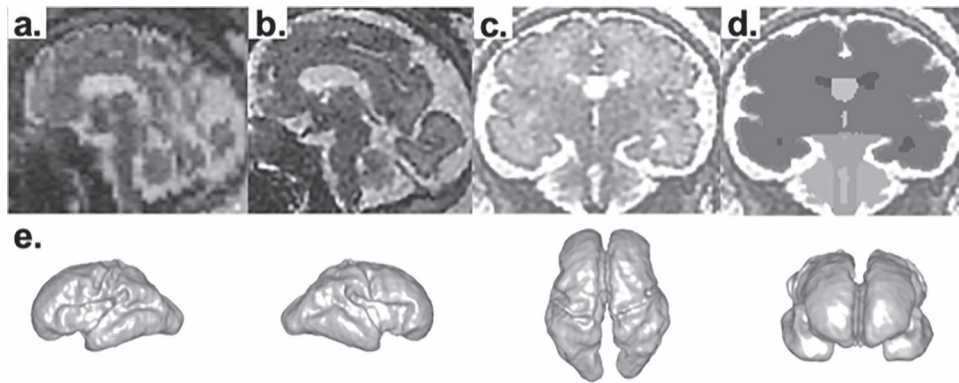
Processing fetal MRI for surface analysis. Raw volume data of fetal MRI (a) is processed with motion correction and high-resolution volume reconstruction to reconstruct 3D fetal brain image (b). In coronal images of reconstructed volume images (c), the regional structures of the brain—cortical plate, subcortical parenchyma, cerebellar hemispheres, vermis, brainstem, lateral-, third-, and fourth ventricles—were manually segmented on each slice using Freeview (d). 3D volume rendering of segmentation data of MRI DS08b (e).
